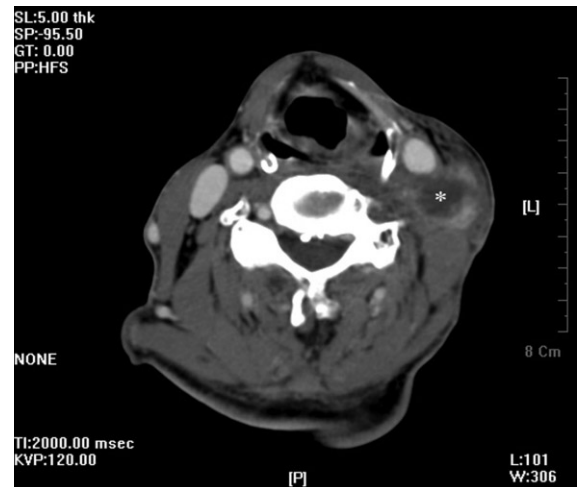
Axial CT scan reveals a neck mass (asterisk) of approximately 3.0×3.0 cm in left level III. (CT: computed tomography)
